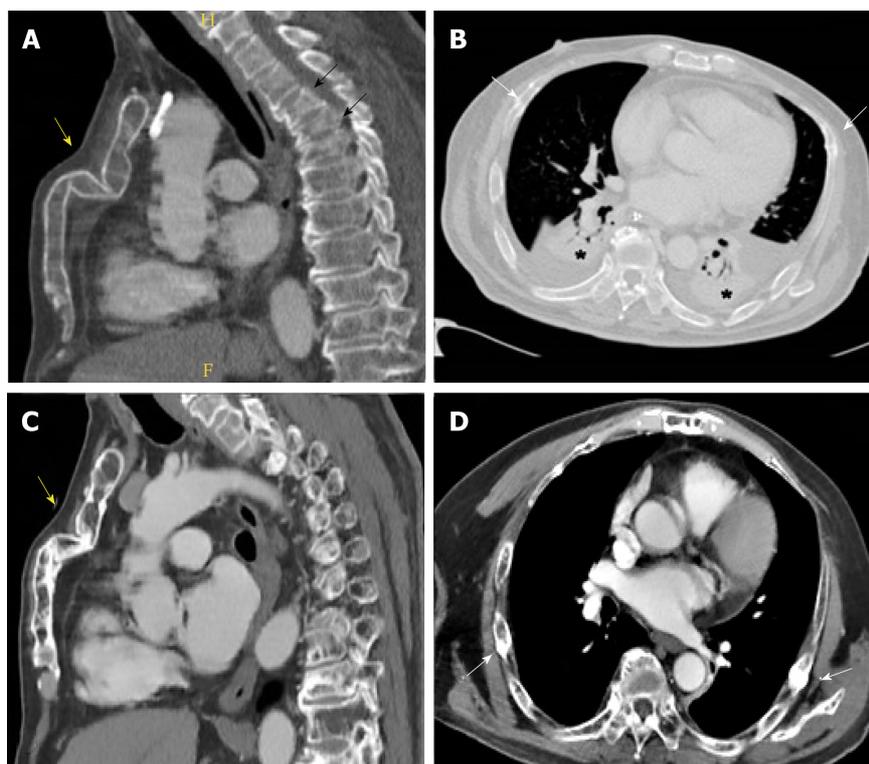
Sagittal computed tomography image. A: A depressed pathological fracture of the sternum (yellow arrow) resulting in an evident deformity of the anterior chest wall. Multiple spontaneous compression fractures of the thoracic spine can also be observed (black arrows); B: Axial computed tomography (CT) image demonstrates multiple rib fractures (white arrows) associated to bilateral lung consolidations (asterisks) and pleural effusion; C and D: Control CT scan, realized months later, shows important improvement of both sternal (C, yellow arrow) and rib fractures (D, white arrows), with the appearance of fracture calluses. Complete resolution of lung consolidations and pleural effusion (D).
